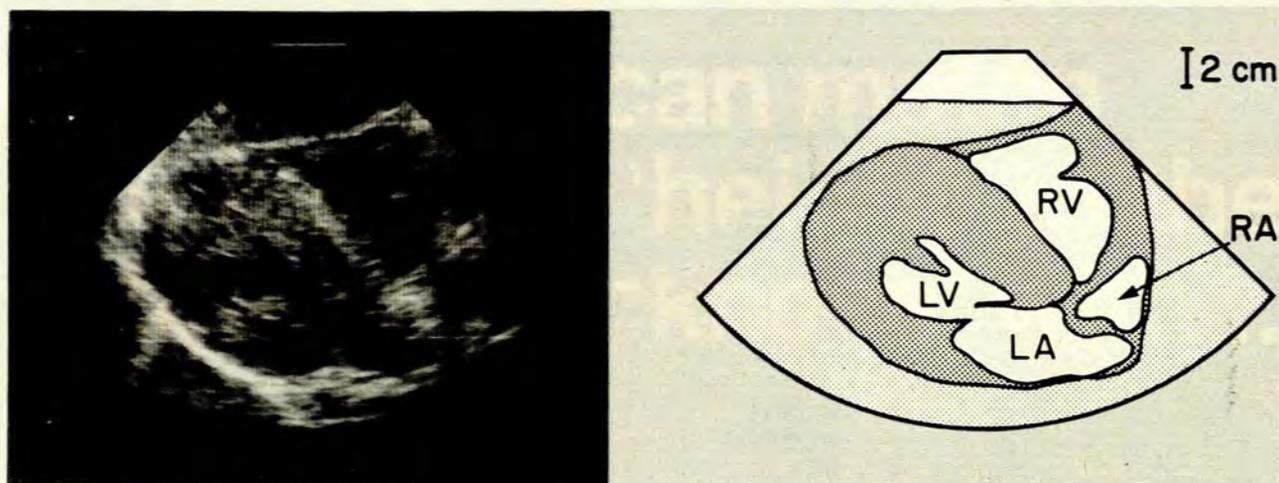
Real-time two-dimensional echocardiogram (subxiphoid four-chamber view) of patient 7 (end-diastolic frame). There is marked LVH, especially of the interventricular septum. The left ventricular cavity is small (RV = right ventricle, LV = left ventricle, LA = left atrium, RA = right atrium).
